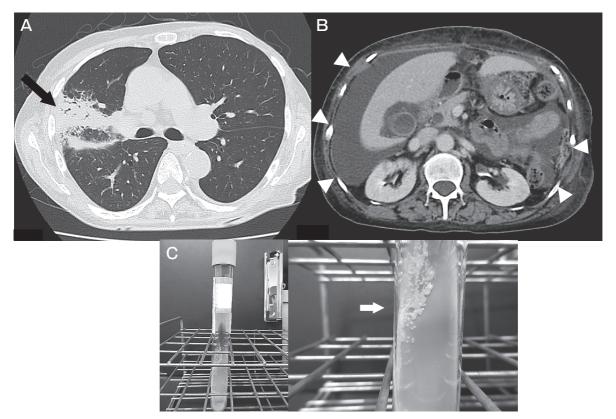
A, Computed tomography of the chest showed an invasive shadow in the upper right lobe (\Rightarrow); B, Computed tomography of the abdomen showed ascites after hepatic cyst surgery (\triangleright); C, Cultured acid-fast bacteria at 2 weeks (\Rightarrow).
